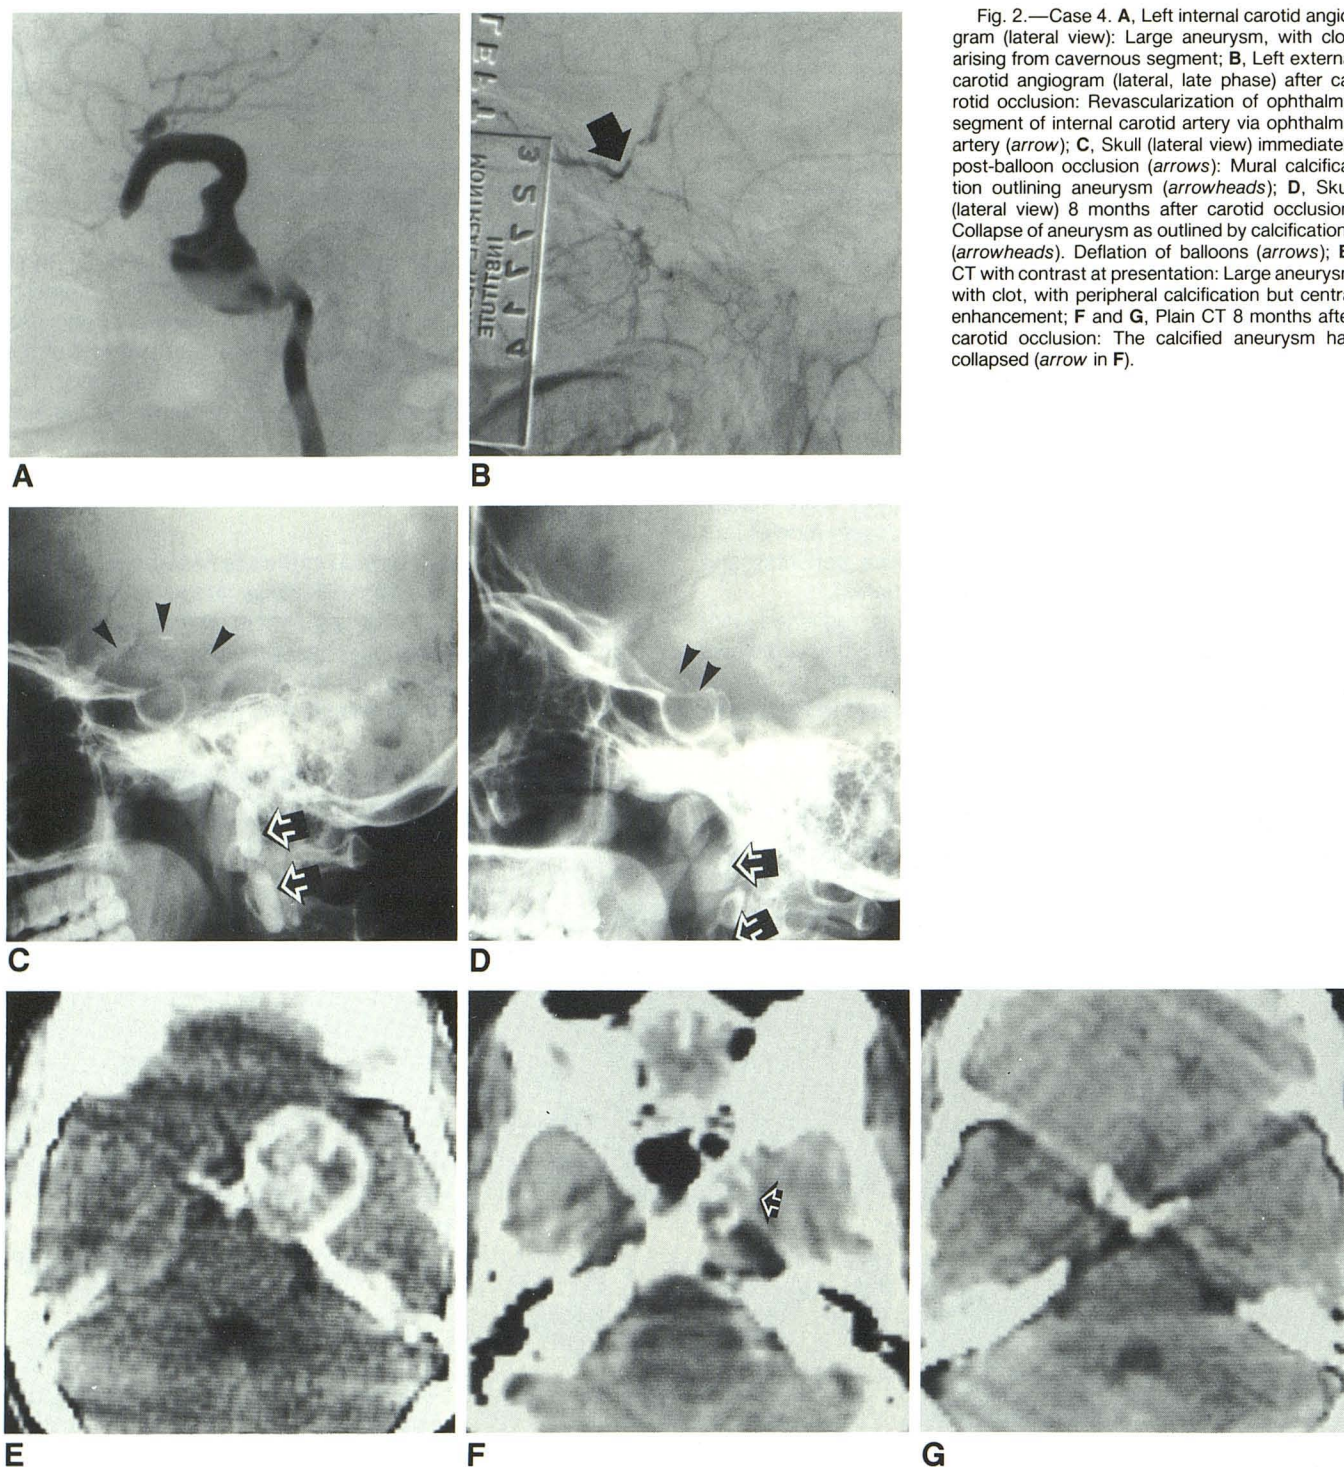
Case 4. A, Left internal carotid angiogram (lateral view): Large aneurysm, with clot, arising from cavernous segment; B, Left external carotid angiogram (lateral, late phase) after carotid occlusion: Revascularization of ophthalmic segment of internal carotid artery via ophthalmic artery (arrow); C, Skull (lateral view) immediately post-balloon occlusion (arrows): Mural calcification outlining aneurysm (arrowheads); D, Skull (lateral view) 8 months after carotid occlusion: Collapse of aneurysm as outlined by calcifications (arrowheads). Deflation of balloons (arrows); E, CT with contrast at presentation: Large aneurysm with clot, with peripheral calcification but central enhancement; F and G, Plain CT 8 months after carotid occlusion: The calcified aneurysm has collapsed (arrow in F).
